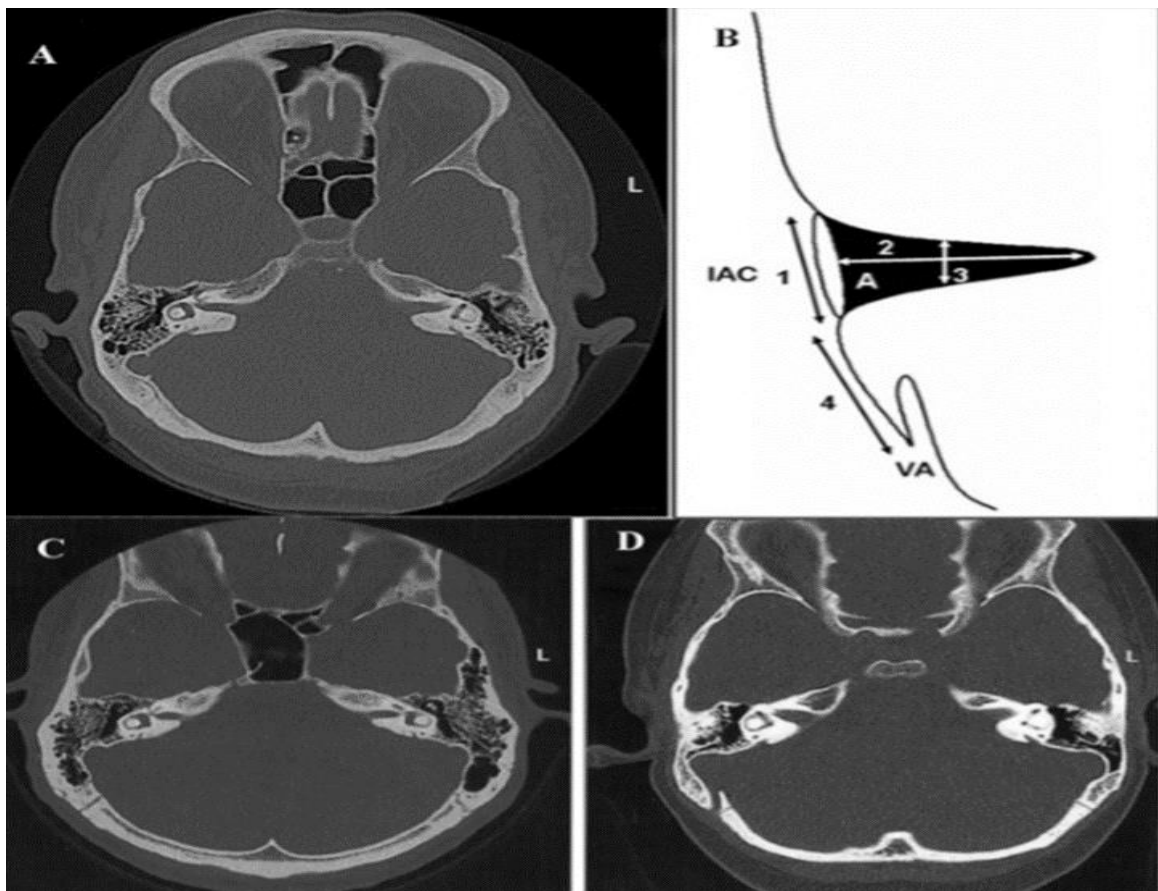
A,C,D CT imaging axial cut at level of IAM , D present diameters of the canal .
